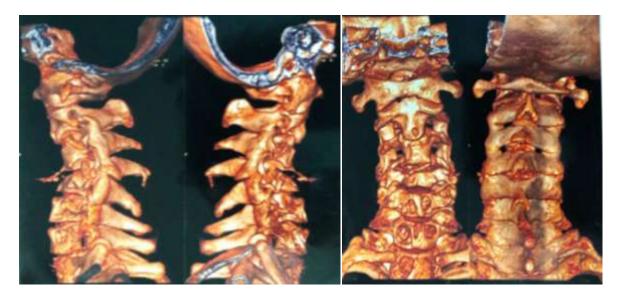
3D Cervical CT-scan
